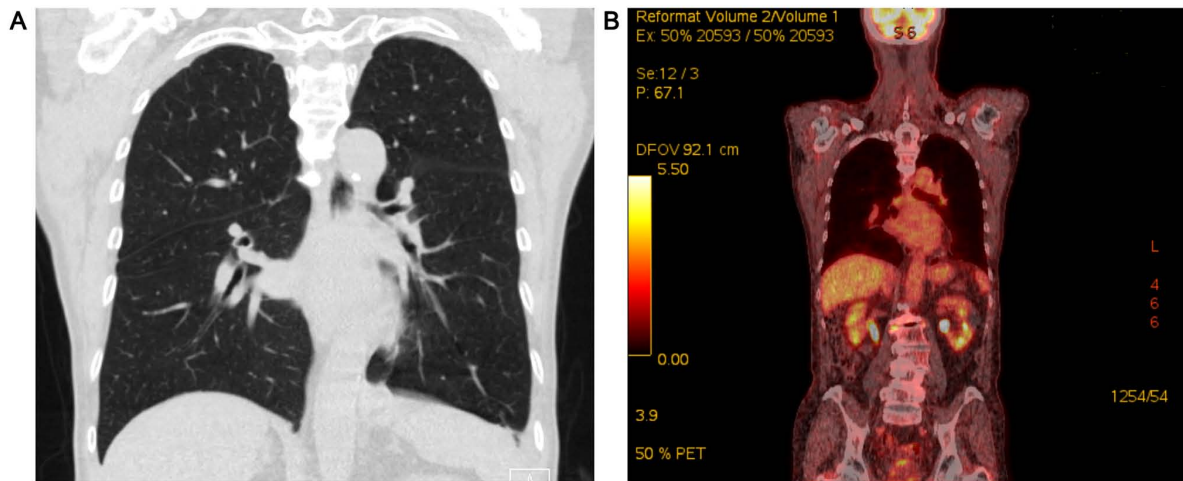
Chest CT and PET-CT scans of the patient. (A) Chest CT revealing left pleural thickening and effusion. (B) PET-CT scan showing mildly increased ^{18}F -fluorodeoxyglucose uptake in the left pleura. CT, computed tomography; PET-CT, positron emission tomography-CT.
